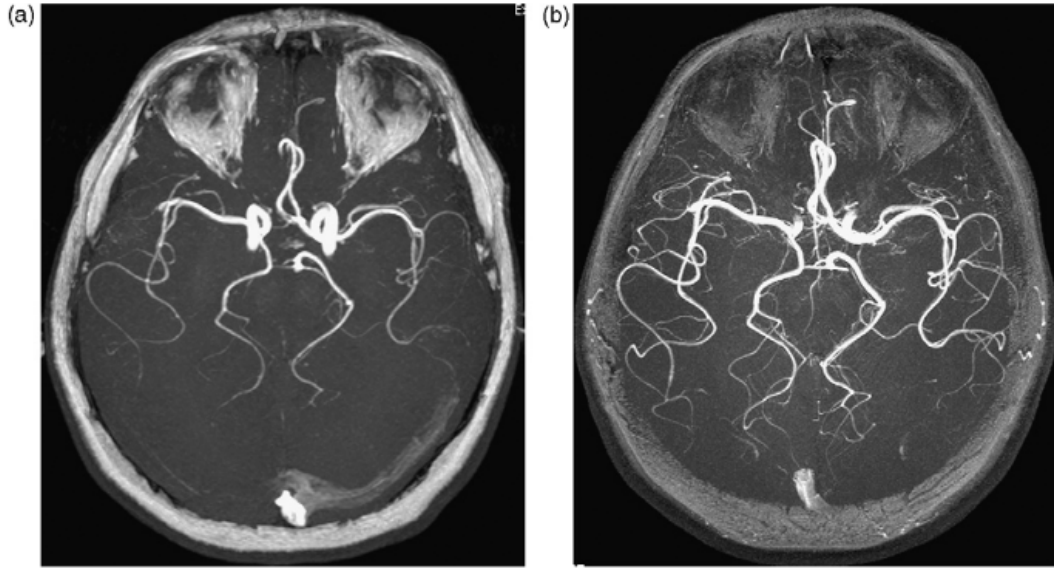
Sample time of flight (TOF) MRA with a 1.5 T MRI field strength acquisition (a) and a 3.0 T MRI field strength acquisition. [1]
